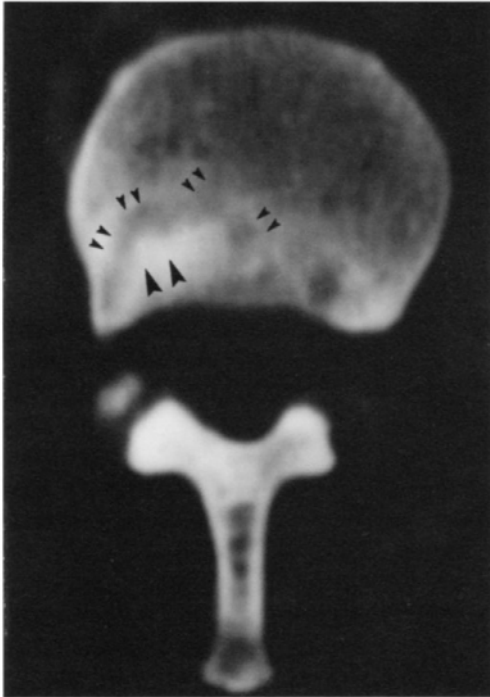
Follow-up CT examination one and a half year later shows centrifugal enlargement of the lesion. The advancing lytic cutting cone (small arrow heads) is followed by osteosclerosis (big arrow heads).
